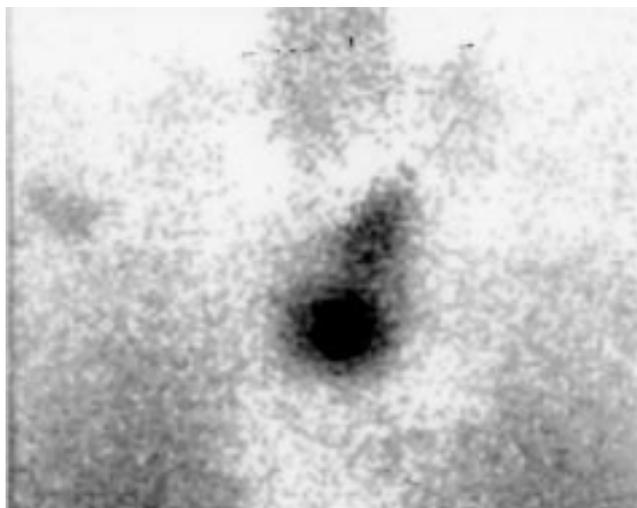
^{99m}Tc - ^{201}Tl subtraction scintigraphy demonstrated abnormal uptake in accordance with the mediastinal tumor.
